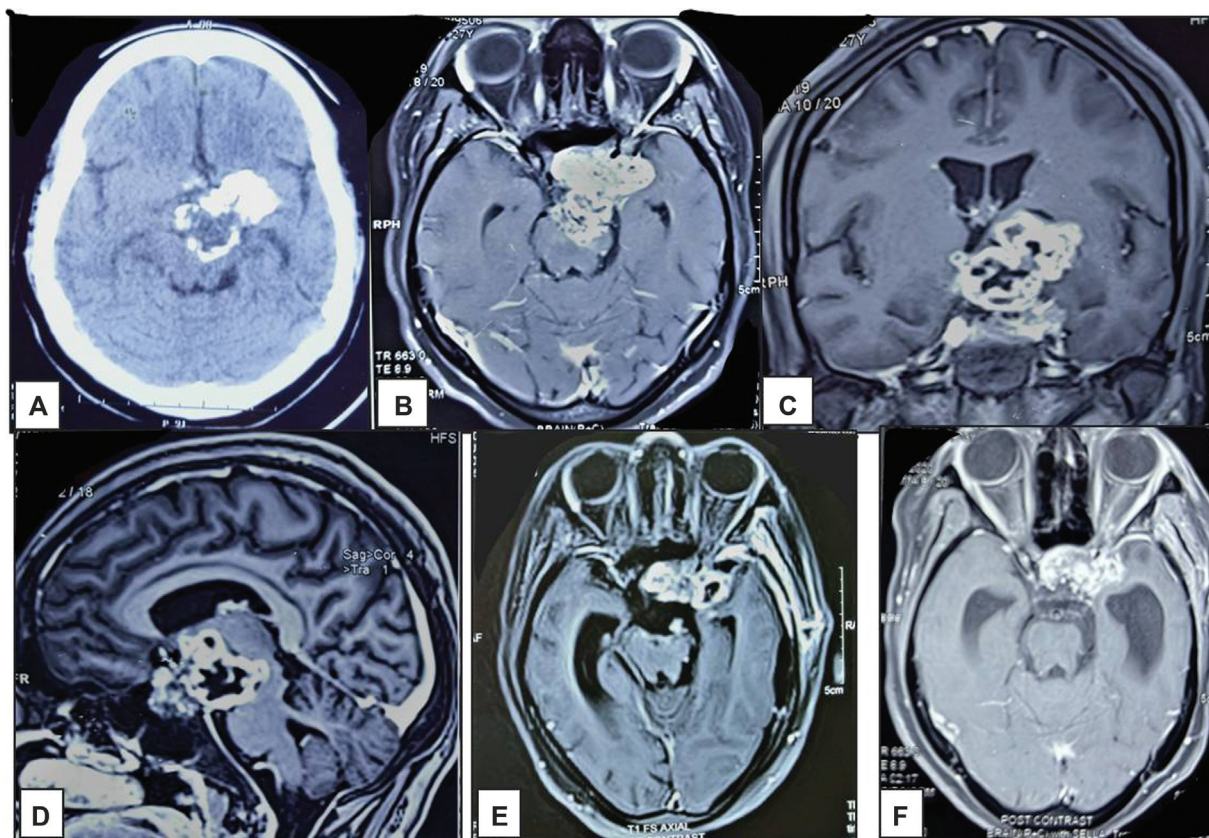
(A) Baseline computed tomography brain showing a large heterogeneous calcified lobulated swelling in sellar-suprasellar region with extension to left parasellar region and brainstem. Contrast-enhanced magnetic resonance imaging (MRI) in (B) axial, (C) coronal, and (D) sagittal sections show a multilobulated heterogeneously enhancing solid-cystic lesion involving sella, suprasellar and left parasellar region, left internal/external capsules, basal ganglia and frontal periventricular regions. Pituitary gland and optic chiasm are not seen separately. The mass is eroding left lateral wall of sella to extend into left cavernous sinus and extra-axial extradural temporal lobe. Left internal carotid artery is completely encased and narrowed. Posteriorly, the lesion extends into interpeduncular cistern with left posterior midbrain infiltration. Moderate dilatation of right lateral and third ventricle seen. (E) Postoperative MRI showing residual disease with reduction in mass effect (F) MRI at 30 months postradiotherapy with stable disease.
